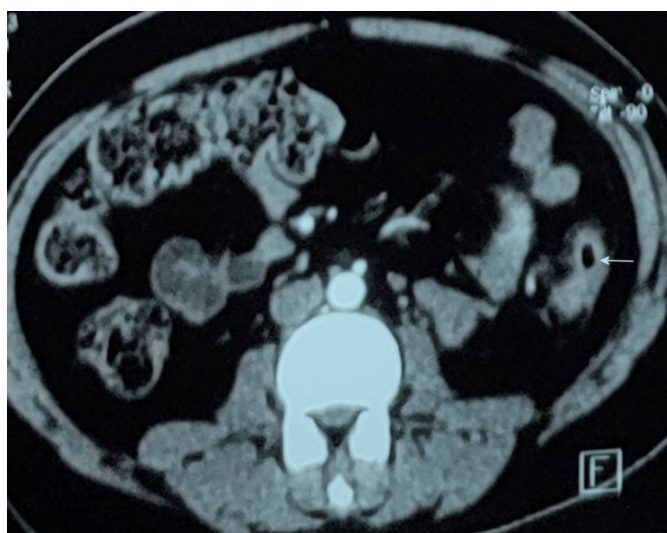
CT Scan abdomen: Diffuse wall thickening at the sigmoid and descending colon (arrow).
